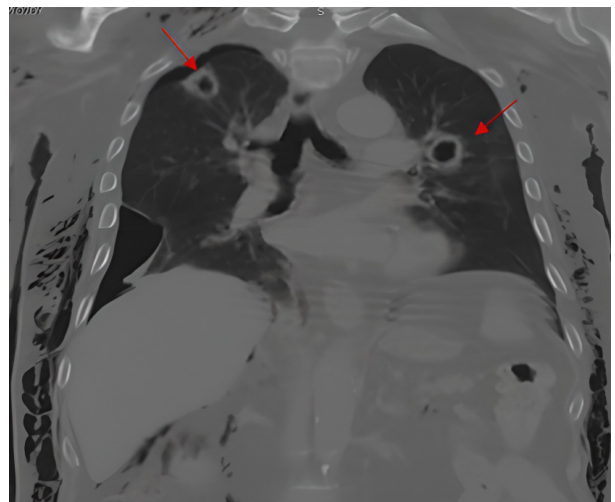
Bilateral cavitory lesions on coronal computed tomography (July 14, 2022)
